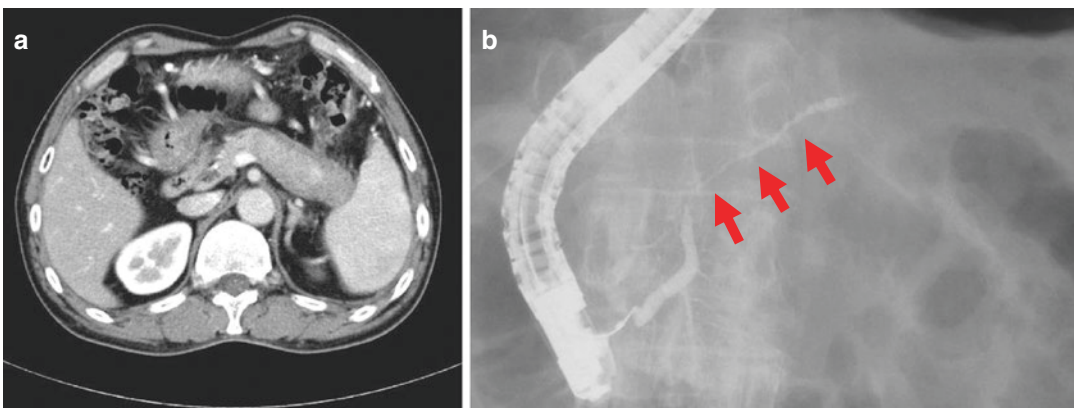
Imaging findings of pancreatic parenchyma and duct in type 1 AIP. (a) Computed tomography image showing diffuse swelling of the pancreas accompanied by
